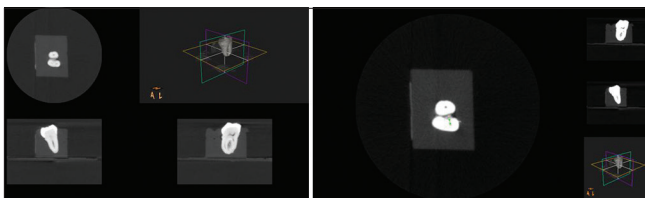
The image of cone-beam computed tomography
